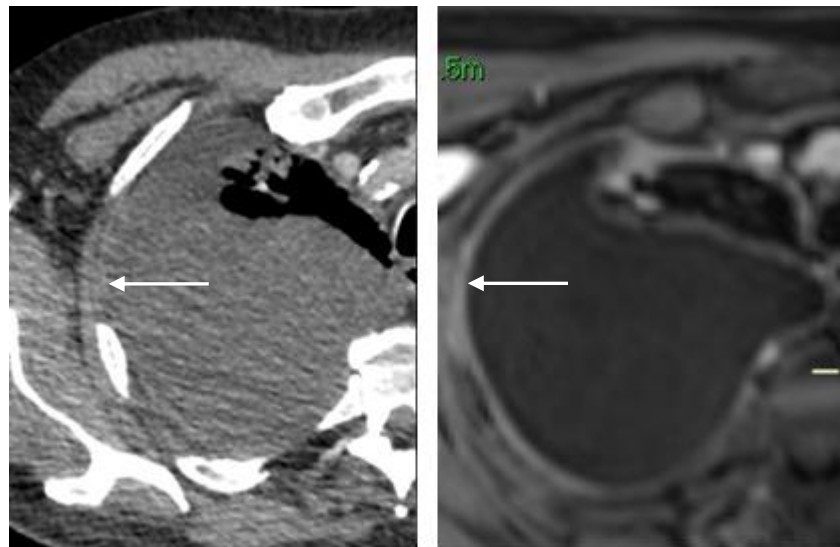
Example of the difference in pleural tumour resolution between a contrast-enhanced CT scan (left) and contrast-enhanced MRI (right) in the same patient. The white arrow denotes pleural enhancement
